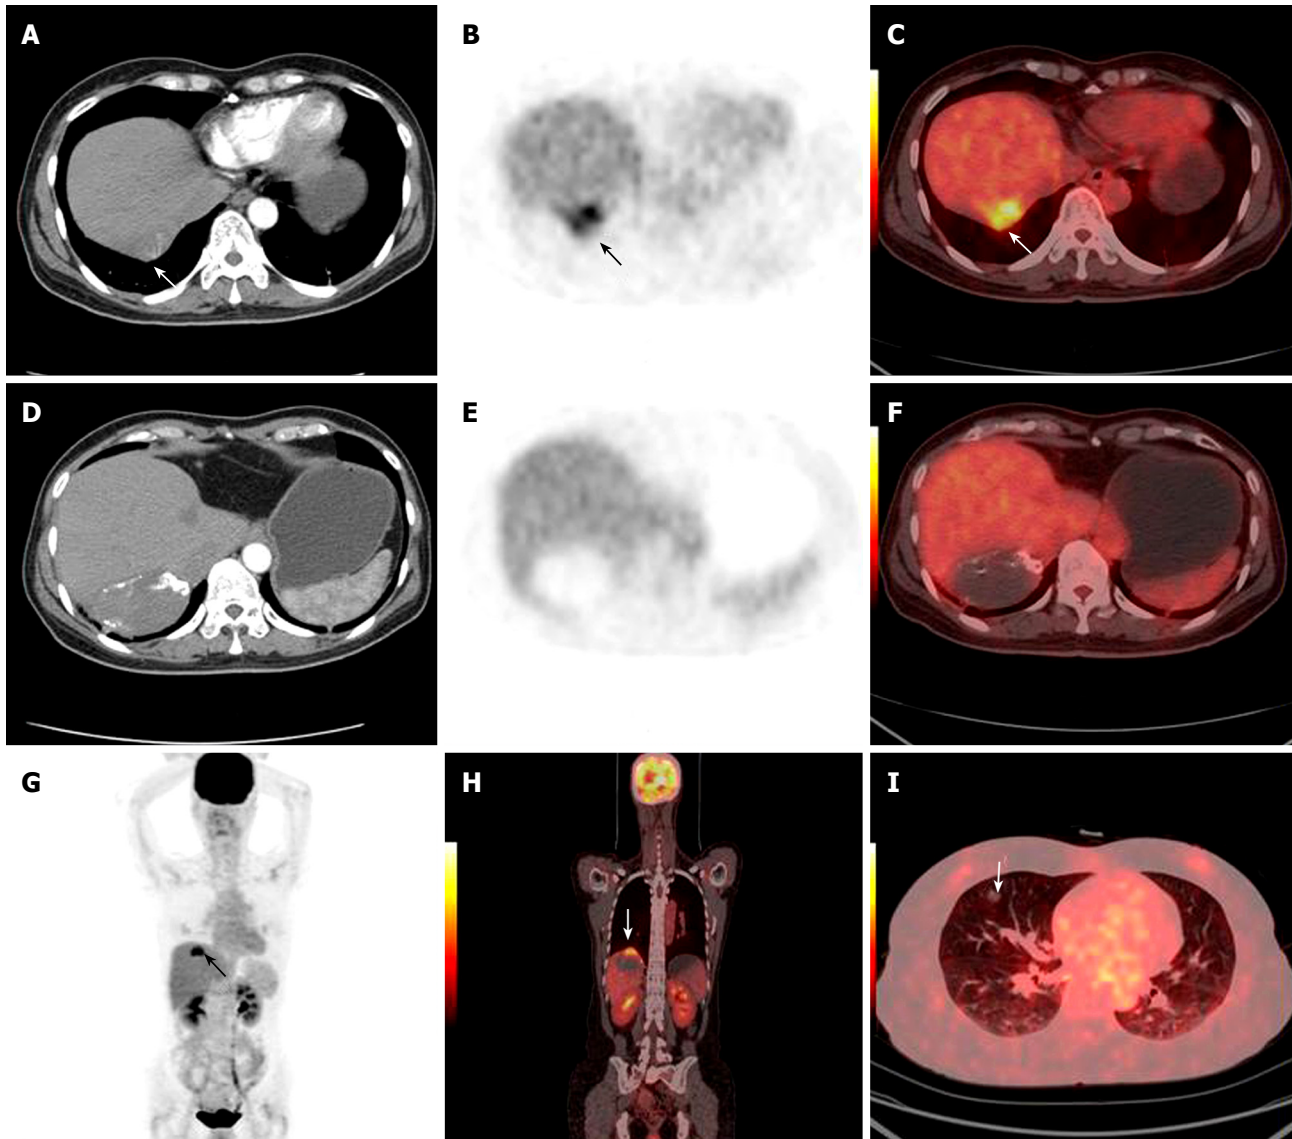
A 50-year woman who had HCC resection 2 years before had an intrahepatic HCC recurrence and received combined RFA and TACE treatment. A highly metabolically active lesion was detected on the top of the lesion by PET and PET/CT fused images (white arrows, A-C and G). Contrast-enhanced CT image showed the non enhanced mass with faint accumulation of iodized oil in the right lobe of the liver (D-F). PET/CT fused images revealed a low FDG uptake benign lesion in the right lung (I). All findings were later verified by clinical follow-up.
